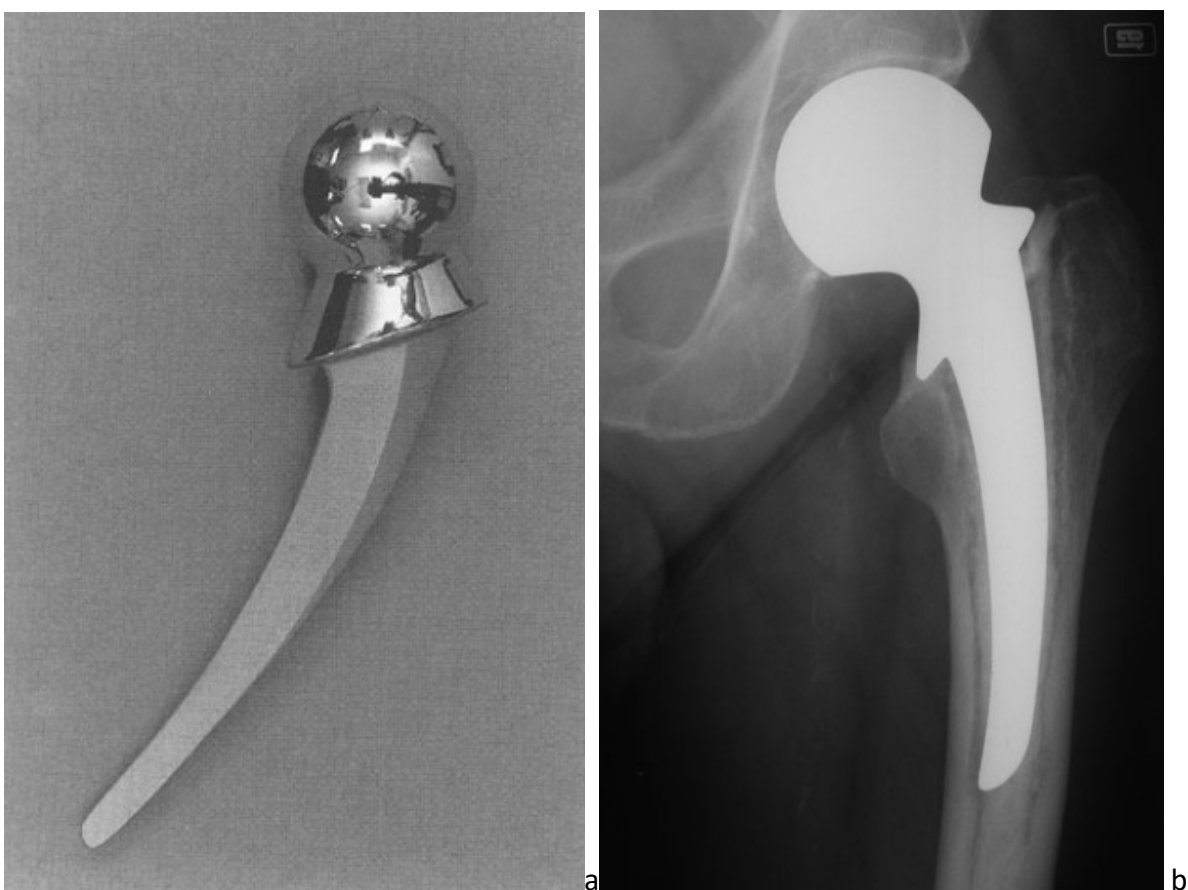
Photograph (a) and radiograph of implanted (b) unipolar hip hemiarthroplasty. Reproduced with permission from Springer (licence number: 4450960195677); [14].
